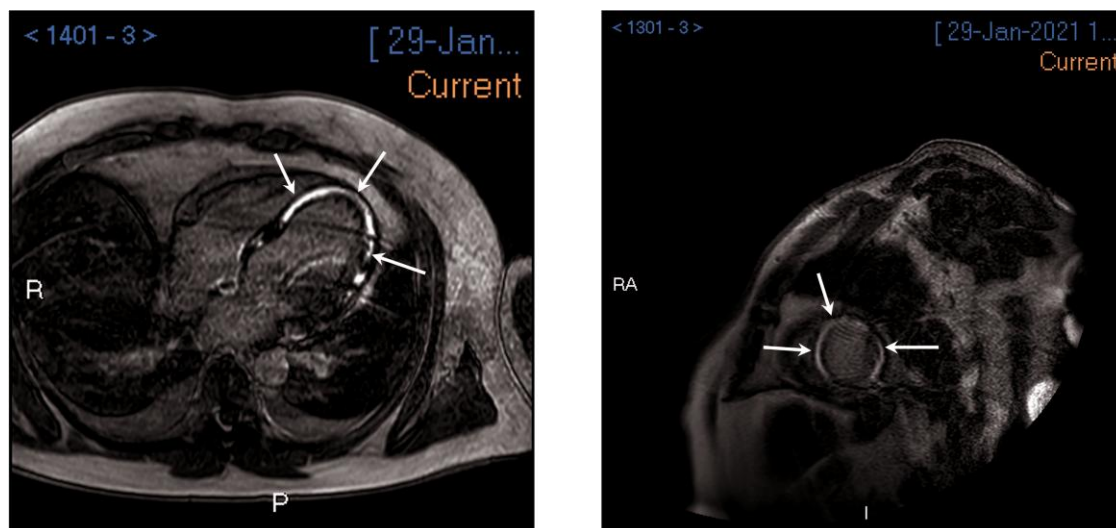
Four-chamber and short-axis T1-weighted inversion recovery images acquired 10 min following the administration of gadolinium-based contrast agent, showing intense global mid-wall myocardial enhancement that is not limited to a coronary artery territory and in keeping with widespread myocarditis-related change.
